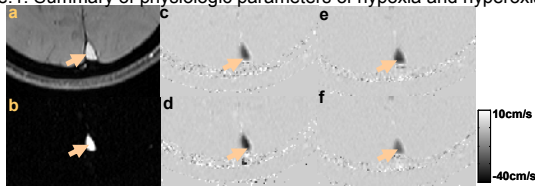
PC MRI at the sagittal sinus: (a) raw image, (b) magnitude image, and velocity map during (c) normoxia, (d) hypoxia, (e) normoxia, and (f) hyperoxia. (d) appears darker than (c) corresponding to a faster blood flow during hypoxia. Also, (f) appears brighter than (e) corresponding to a slower blood flow during hyperoxia. Arrows indicate the sagittal sinus.
